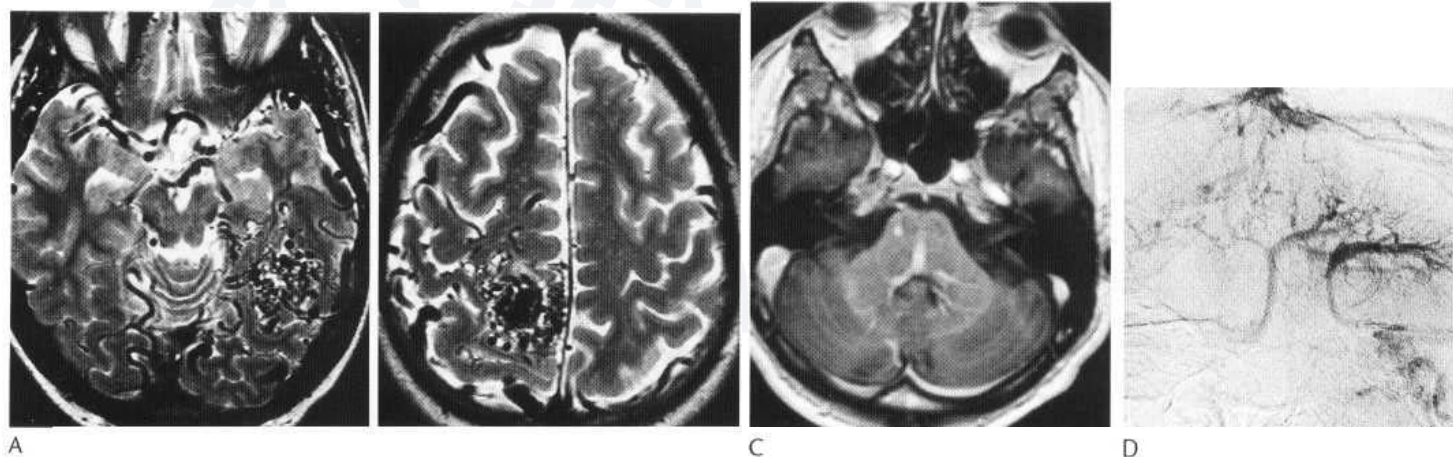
(A,B) Extensive bilateral AVMs are demonstrated on these two axial T₂-weighted MR images. There are multiple enlarged superficial drainage veins. (C) Axial MR shows transpontine venous angioma. (D) Angiogram shows abnormal drainage veins.
